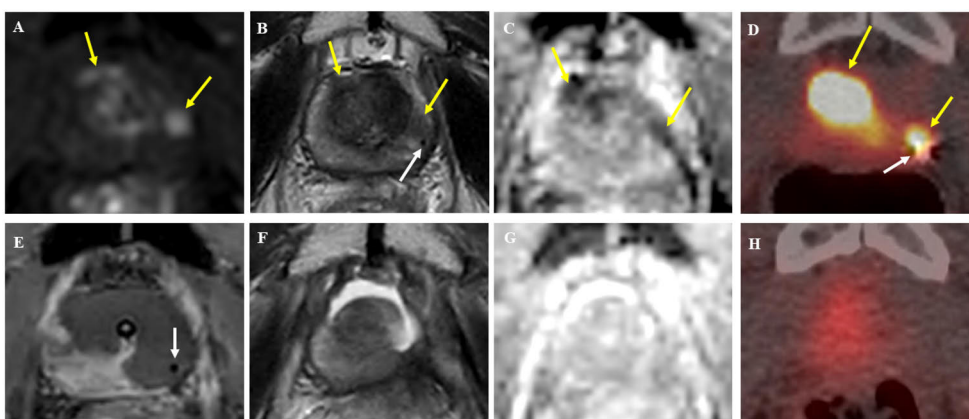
Baseline MRI imaging revealed two index lesions, seen by early enhancement (a), hypointensity (b) and diffusion restriction (c), while PSMA-PET/CT revealed concordant uptake (d). CE-imaging immediately after TULSA (e) revealed non-perfused volume extending to prostate capsule. MRI imaging at 12 months revealed a fluid-filled cavity (f) and the absence of any diffusion restriction (g). PSMA-PET/CT imaging at 12 months showed no regional uptakes and the disappearance of the markers inside the prostate. (From original publication II)
